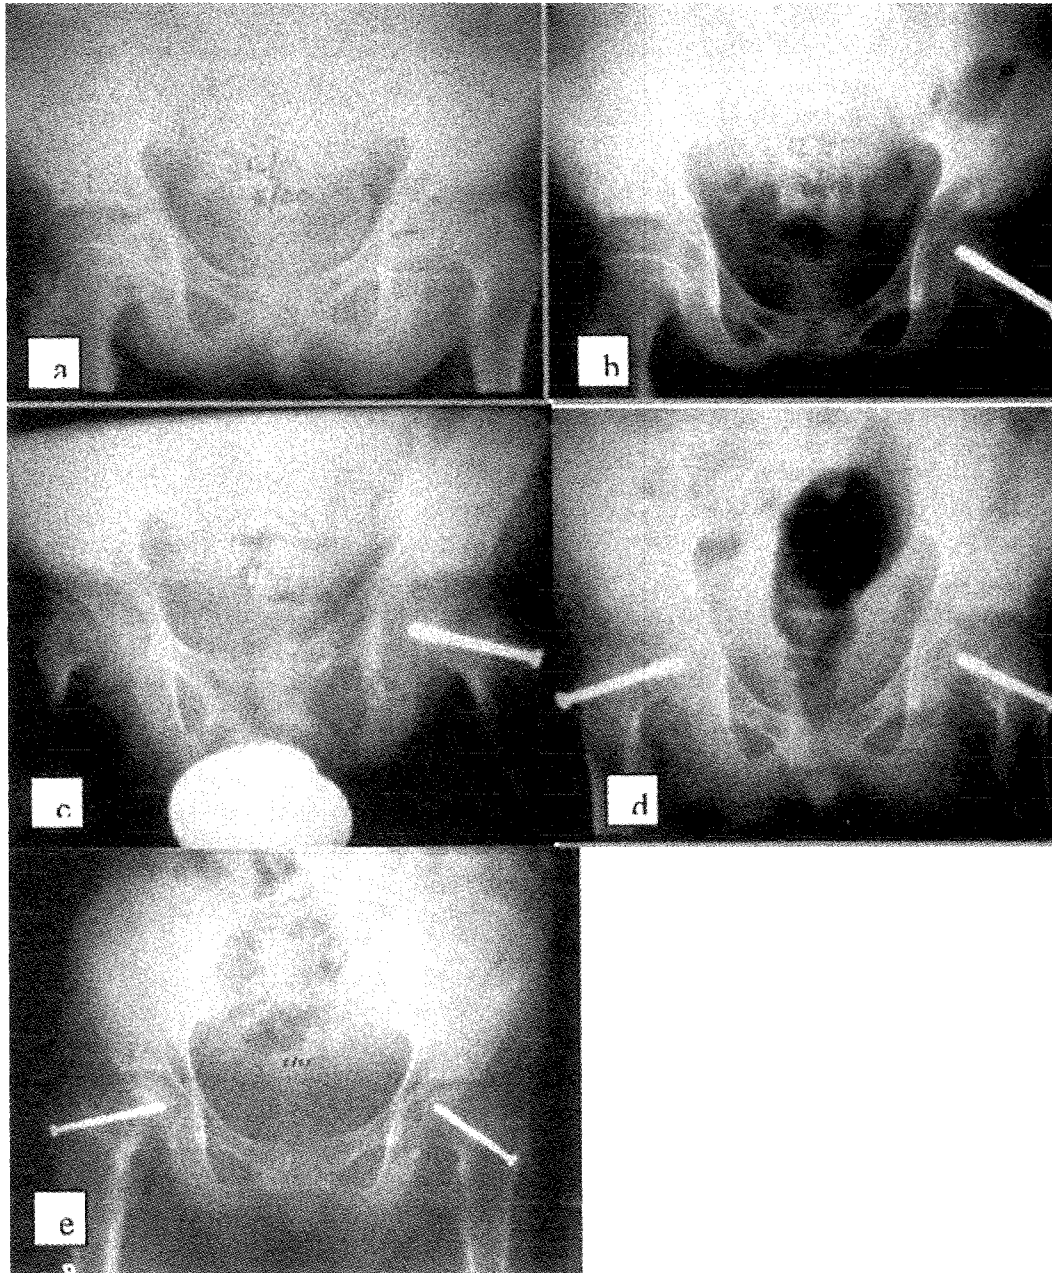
(Case 7) - A 12 year-old boy diagnosed to have panhypopituitarism secondary to a craniopharyngioma, at the age of 9 years, developed left hip pain 2 weeks before admission. (a) Radiograph showed left hip SCFE (b) He was treated with an in situ cannulated screw fixation. (c) Three months later, the right hip had slipped. (d) The right hip was treated with a single in situ cannulated screw. (e) The latest radiograph 5 years post-surgery showed no AVN. He was asymptomatic.
